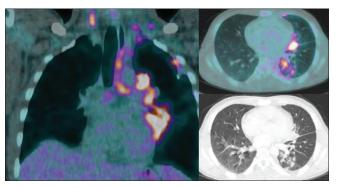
<sup>18</sup>F-fluorodeoxyglucose positron emission tomography/computed tomography and computed tomography images show multiple areas of consolidation with high uptake of <sup>18</sup>F-fluorodeoxyglucose in the left lung and many hypermetabolic lymphadenopathies in the left pulmonary hilum, mediastinum, and neck region
